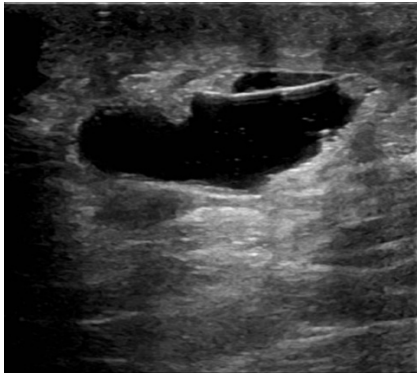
Ultrasonographic image of the lesion.
